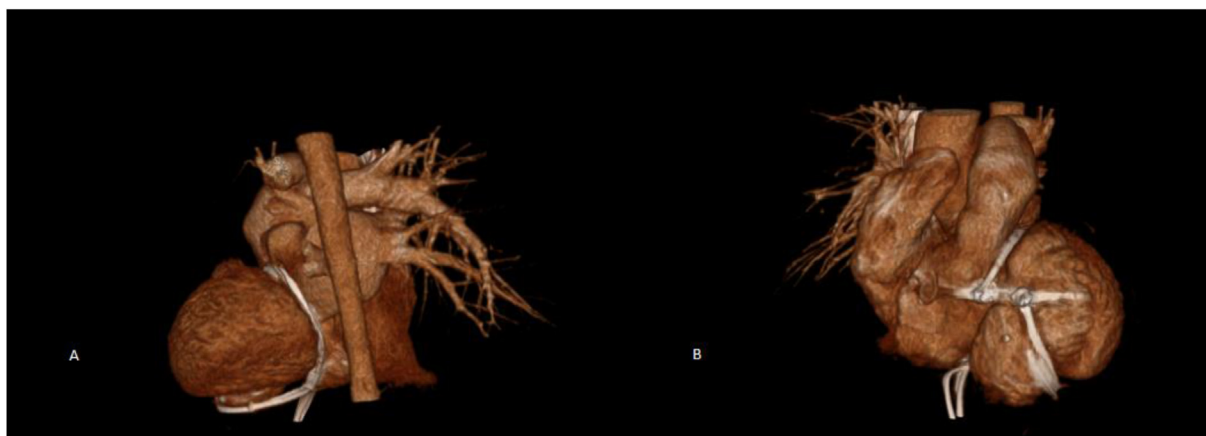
A) Posterior CT angiography reconstruction demonstrating epicardial lead traversing from base of heart up the AV groove. B) Anterior CT angiography reconstruction demonstrating end course of epicardial lead inferior to the RVOT tract.
